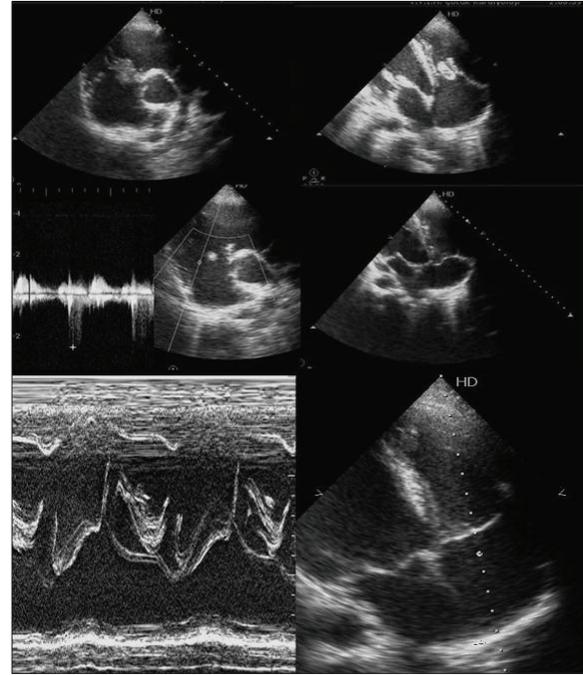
Four-chamber, parasternal short-axis, and M-mode transthoracic echocardiographic views of myxomatous structure and prolapse of tricuspid valve. The continuous wave Doppler examination shows mild tricuspid regurgitation
